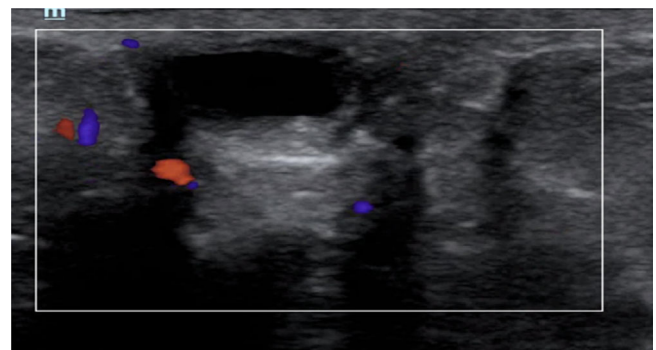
Sonographic image of mass, transverse plane (13-6 MHz linear-array transducer with color flow)
